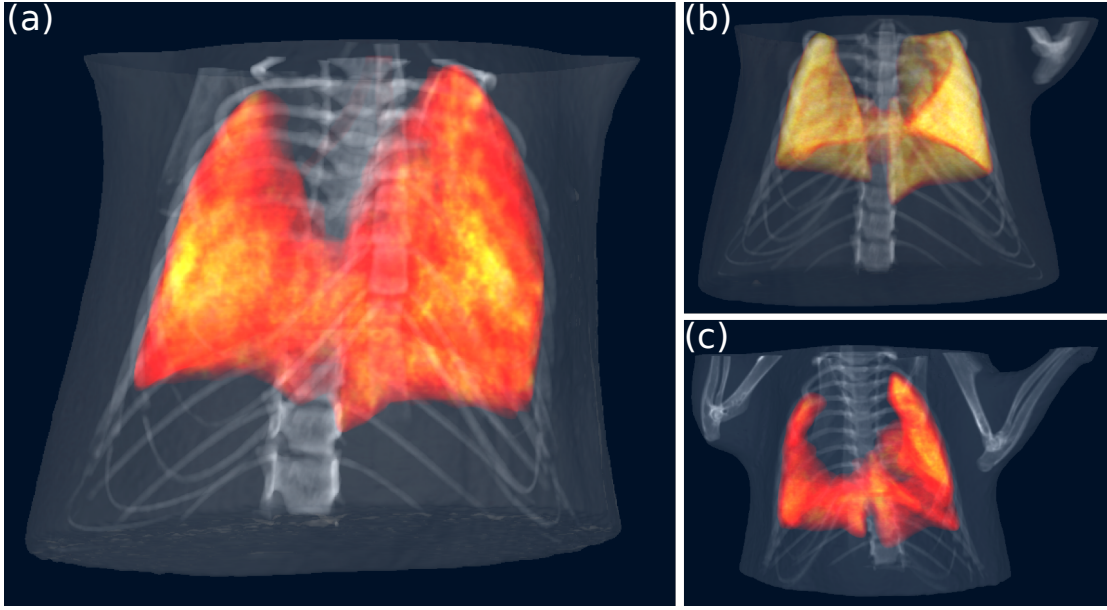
Volume renderings of (a) emphysematous, (b) control and (c) fibrotic case. The skeletal structure was segmented from attenuation CT, whereas the lung tissue was extracted from dark-field CT and represented by a semi-transparent hot color map.
